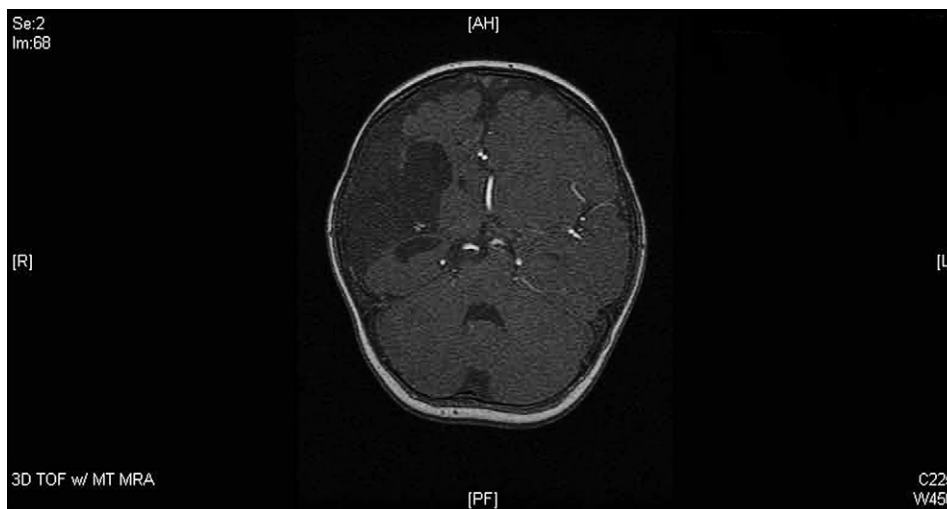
Computed tomography scan of patient status post right hemispherectomy of parietal, temporal, and frontal lobes, patient 4.
